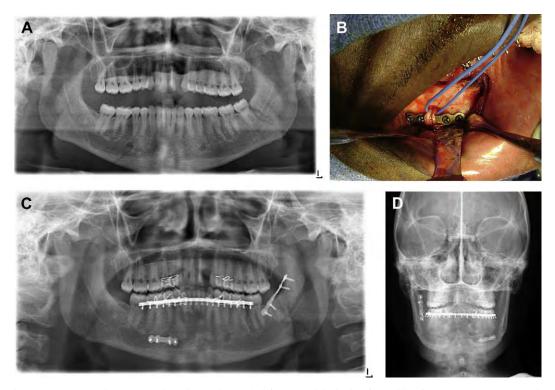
(A) Preoperative panoramic radiograph reveals left angle, right body of mandible fractures. (B) Intraoperative photo shows placement of the 2-mm LMP and screws inferior to the retracted mental nerve. (C, D) Postoperative panoramic and PA radiographs confirm anatomic reduction and fixation with 2-mm LMP and four 8-mm by 2-mm locking screws at the left external oblique ridge and inferior to the right mental foramen.
